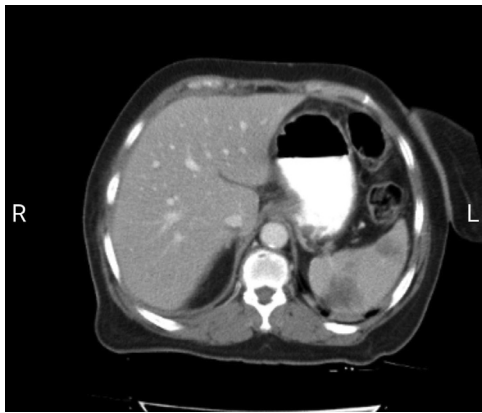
Craniocaudal contrast-enhanced CT images of the abdomen show multiple segmental infarction of the spleen.
